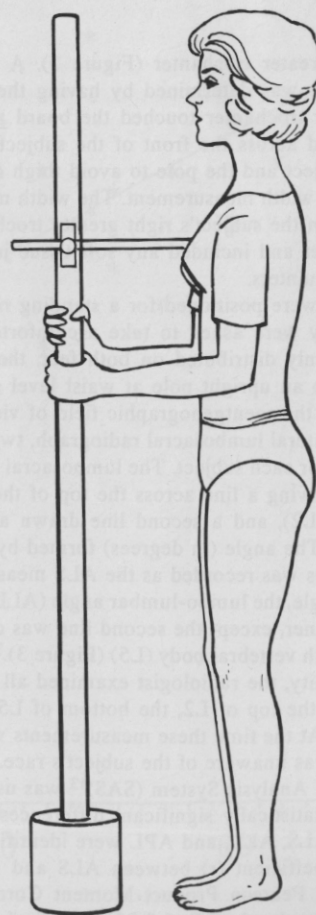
Subject positioning for right lateral lumbosacral radiograph.
